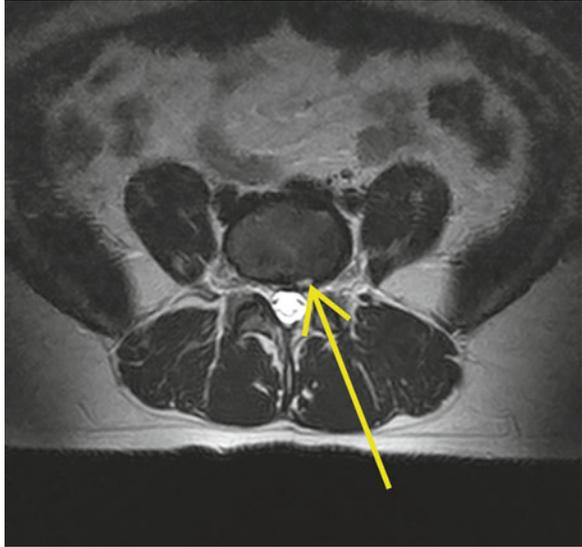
T2-weighted axial images of an L4–L5 annular tear
